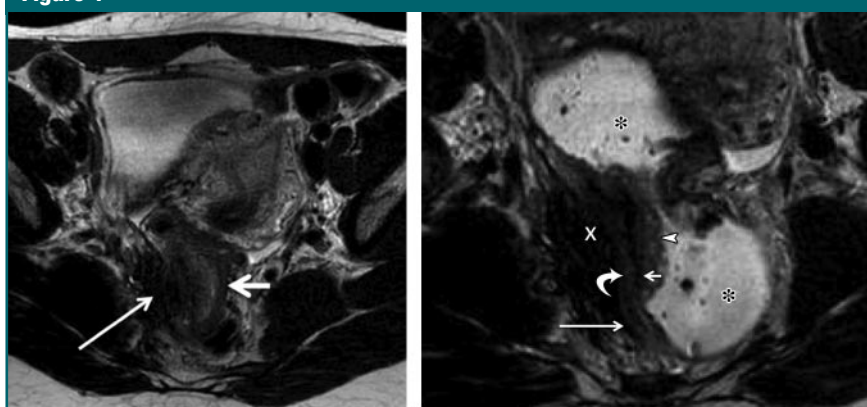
(a, b) Axial high-spatial-resolution TSE T2-weighted flow-compensated T2-weighted MR images (repetition time, respiratory period; echo time, 135 msec) in 21-year-old woman. (a) There is deep endometriosis infiltrating the right USL (short arrow), pelvic muscle, and colon wall (long arrow). (b) Image shows circumferential rectosigmoid stenosis due to deep endometriosis (x) visualized after administration of intrarectal US gel (* = rectosigmoid lumen filled with gel). The different sublayers can be distinguished (arrowhead = mucosa, short straight arrow = submucosa, curved arrow = muscularis, long straight arrow = serosa). At MR imaging and pathologic examination, the colon wall infiltration was graded as involving the mucosa.
